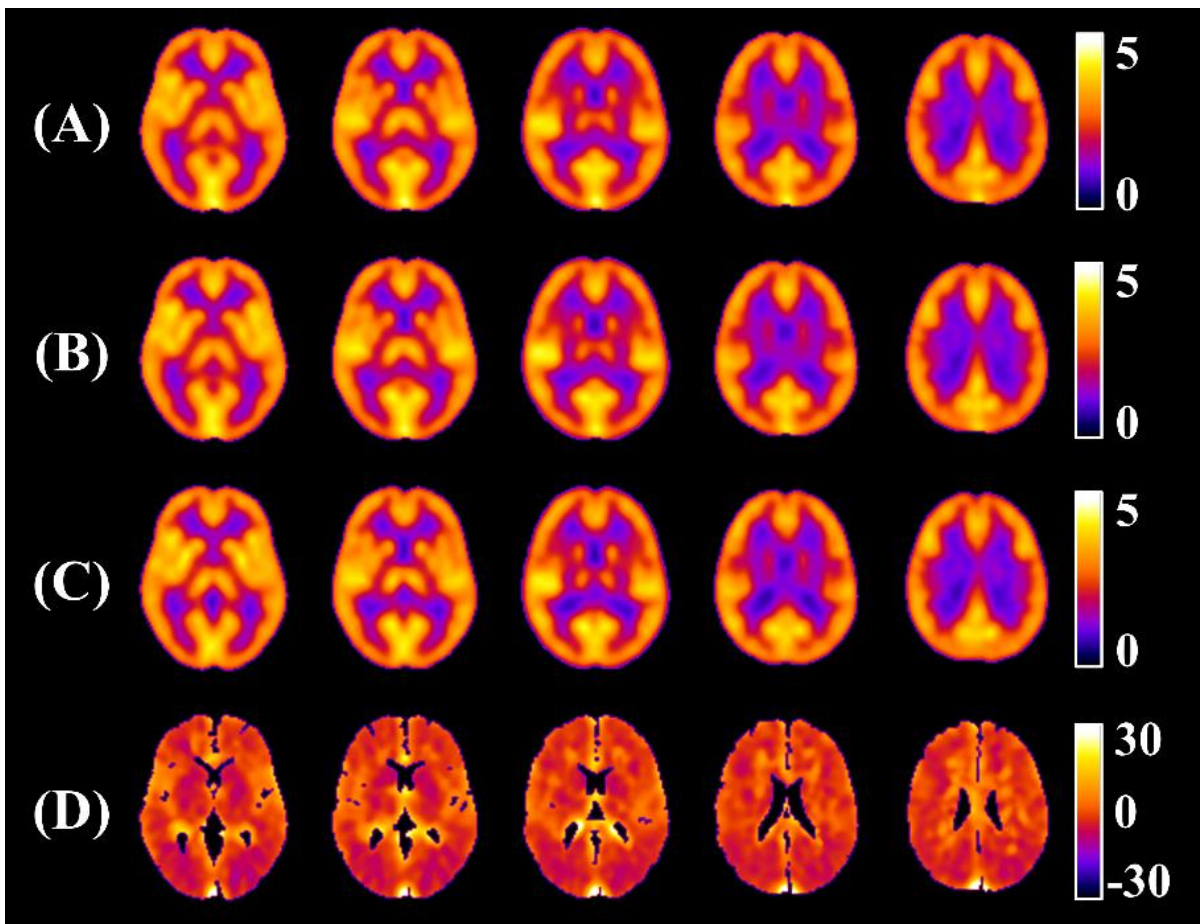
CMRO₂ images obtained with the reference-based method. CMRO₂ images (mLO₂/100 g/min) obtained with the reference-based method applied to [¹⁵O]₂-PET data from healthy volunteers ($n = 10$) for integration times of 3 (A) and 5 min (B), compared to DARG images (C). (D) Images of the relative difference (%) between the 5-min reference-based and DARG CMRO₂ images. Non-brain regions were removed by masking the corresponding anatomical T₁-weighted MR images. All images were normalized to the MNI space.
